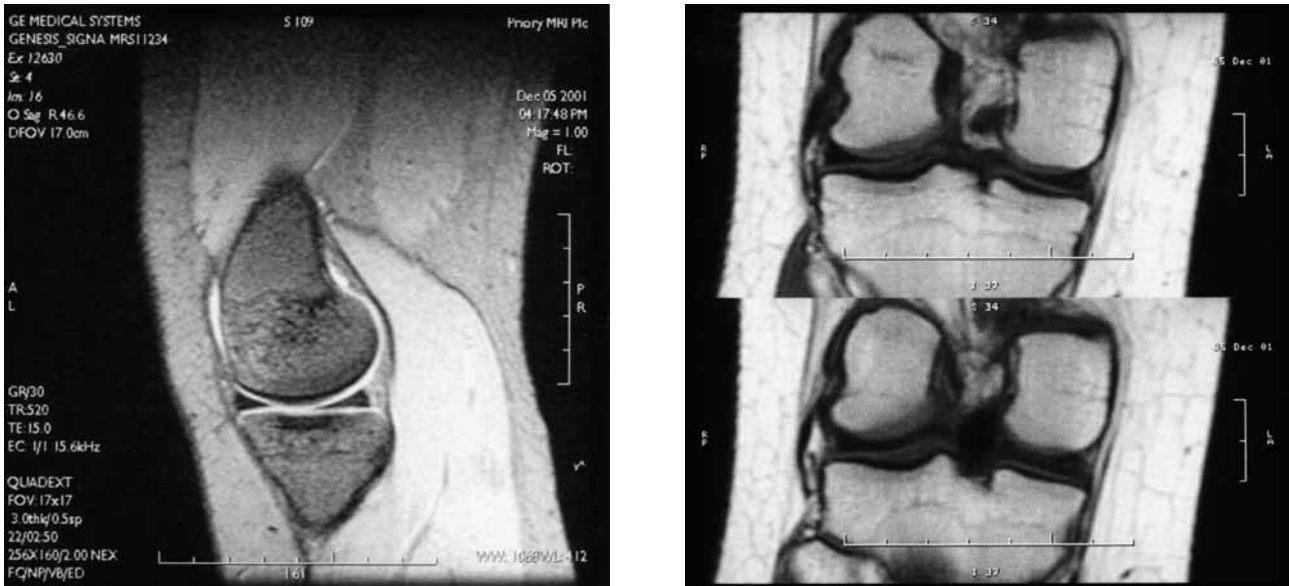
Normal appearance of the knee joint on MRI scan.
